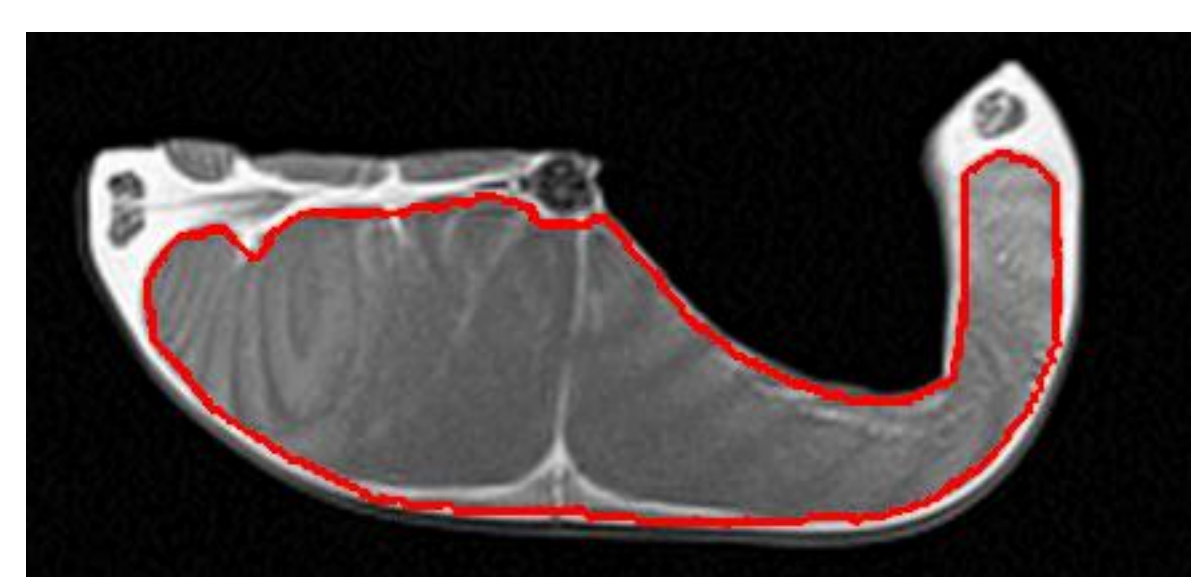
MR image of a half-cutlet. The average signal intensity inside the region delimited in red was computed. The flesh was then cut, crushed, dried and analysed for the lipid content measurement by NMR.
